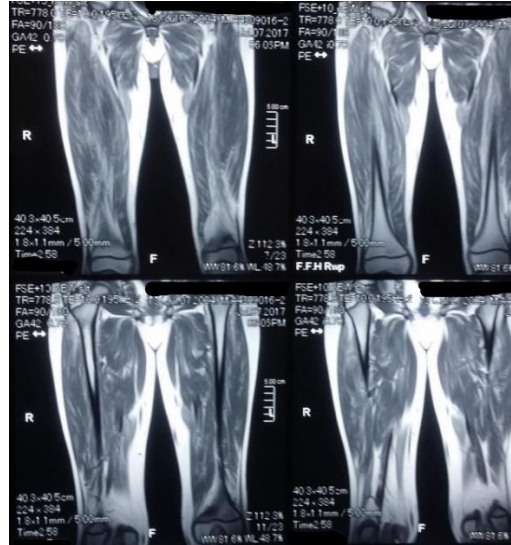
Coronal MRI of Thighs: Muscle Edema along with atrophic changes involving both thighs. MR features are suggestive of acute on chronic polymyositis.
